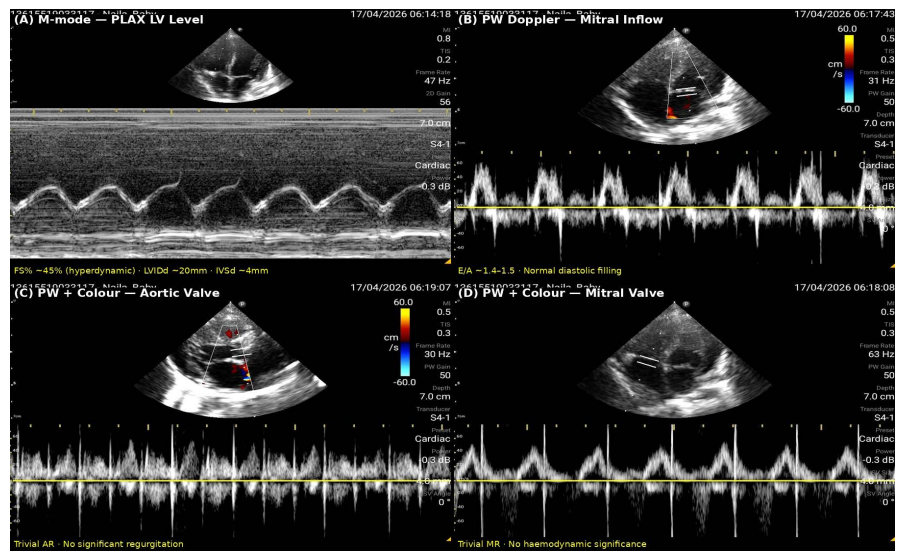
M-mode and PW Doppler—Day 28 (17-Apr-2026). (A) M-mode at PLAX LV level: fractional shortening ~45% (hyperdynamic; normal 28% - 44%), LVIDd ~20 mm (small for age), IVSd ~4 mm, and LVPWd ~4 mm (normal). Quantitative confirmation of hyperdynamic LV function with low SVR. (B) PW Doppler mitral inflow: E wave ~45 - 50 cm/s, A wave ~30 - 35 cm/s, E/A ratio ~1.4 - 1.5 (normal for age)—no diastolic dysfunction, normal filling pattern. (C) PW Doppler with color at the aortic valve: trivial AR only. (D) PW Doppler with color at mitral valve: trivial MR confirmed on spectral trace. Mindray S4-1, cardiac preset, SV 4.0 mm.
